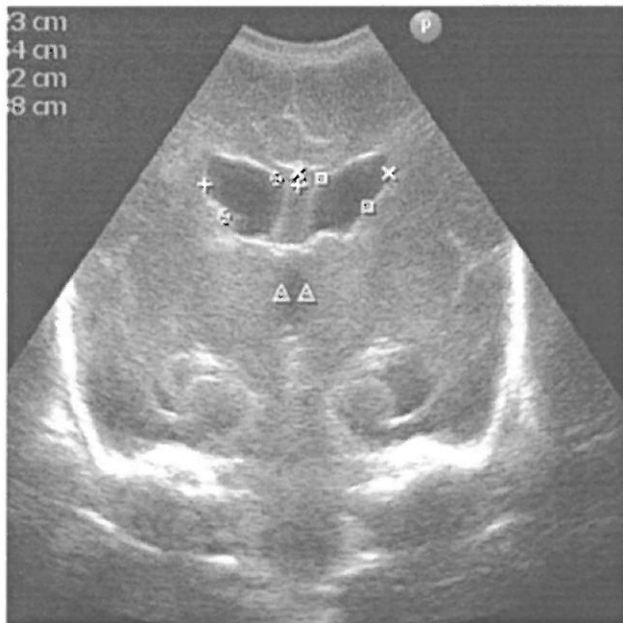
Cranial ultrasound scan showing moderate dilatation of the lateral ventricles. Coronal view with callipers showing anterior horn width (denoted by square callipers), third ventricular width (triangular callipers), and ventricular index ('X' and '+' callipers) measurements.
